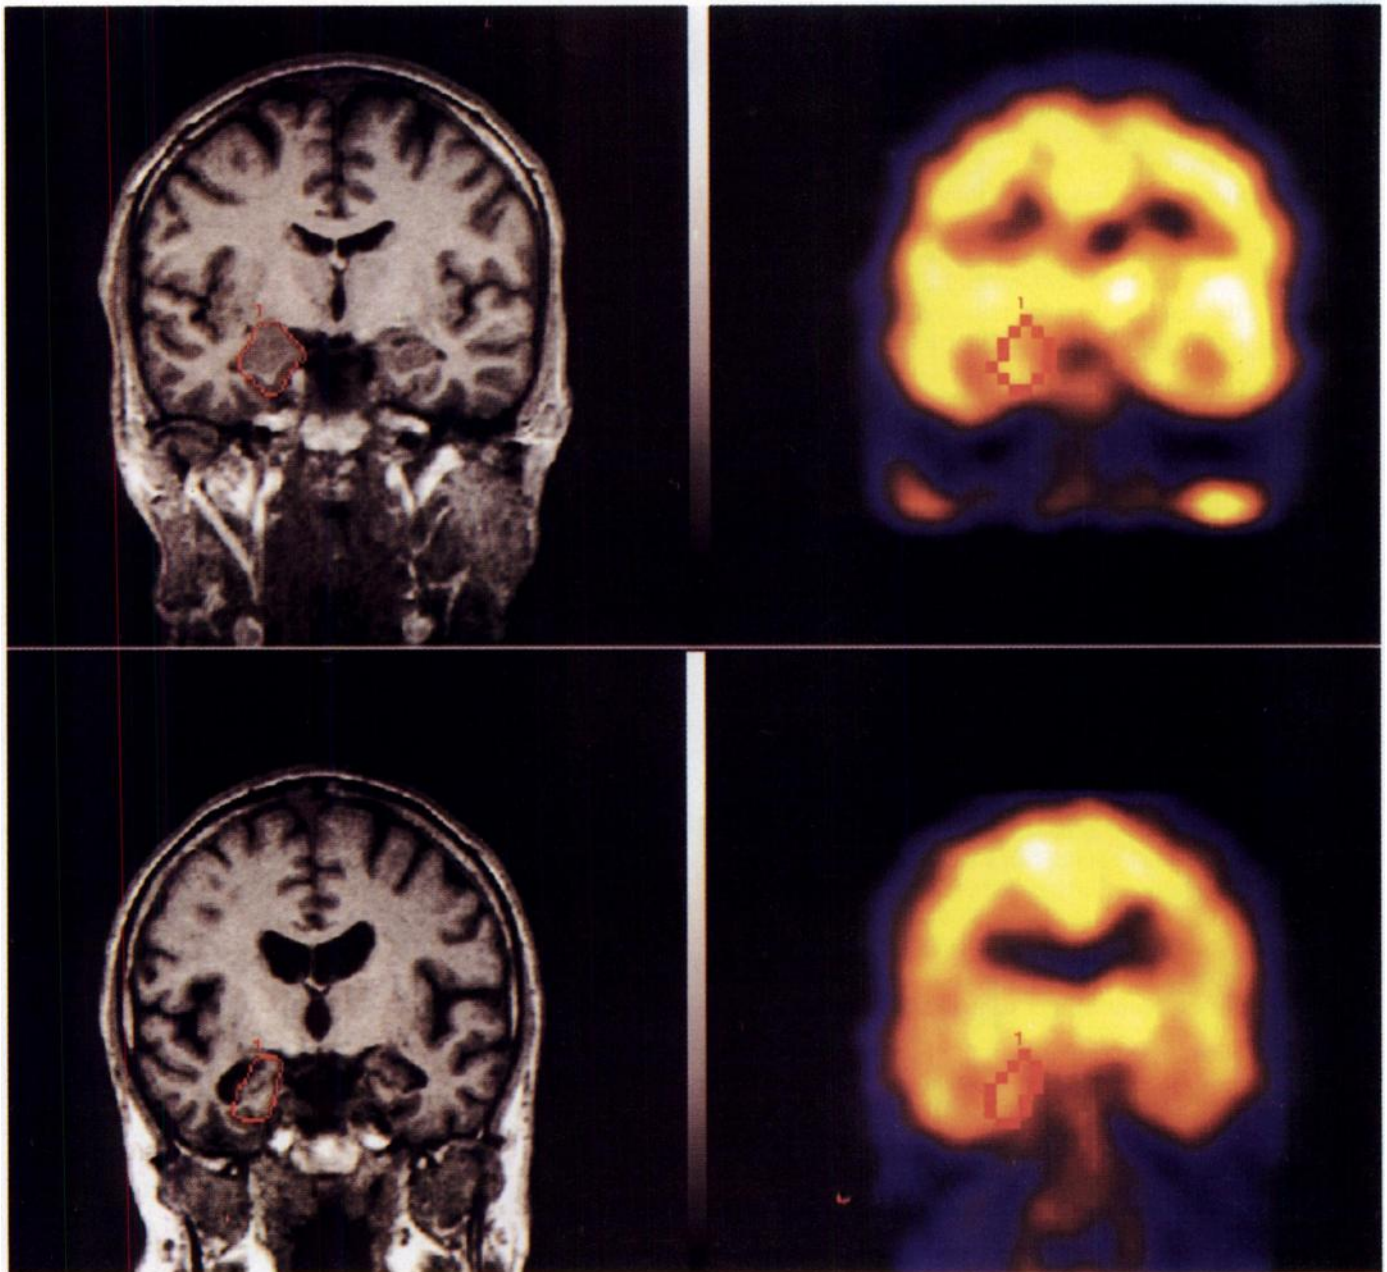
Medial temporal ROIs in coronal MR and SPECT images from a healthy control subject (top row) and an AD patient (bottom row), MRI (left) with manually outlined MTL-ROIs and SPECT (right) with the MTL-ROIs transferred from MRI. Both the mean volume and the mean CBF ratio of the MTL-ROIs were lower in AD patients as compared to the control subjects.
